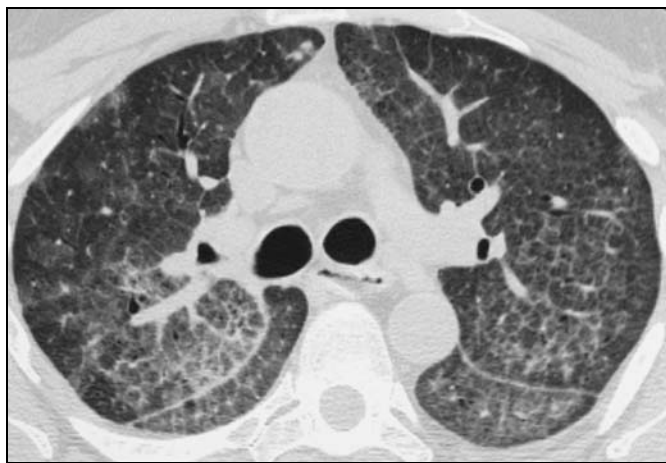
46-year-old woman with sarcoidosis who presented with dyspnea and had restrictive pulmonary function tests. High-resolution CT image through carina reveals ground-glass opacities composed of many faint centrilobular nodules widely distributed throughout lungs.
